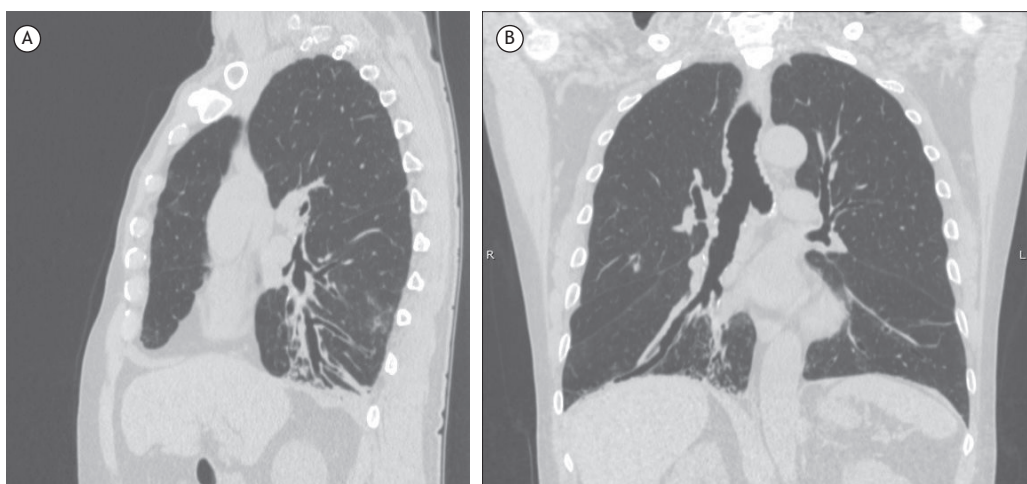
In A, sagittal chest CT scan demonstrating bronchiolectasis, atelectasis, and areas of ground-glass opacity in the lower lobes. In B, coronal chest CT scan demonstrating better visualization of bronchiolectasis in the right lower lobe.
